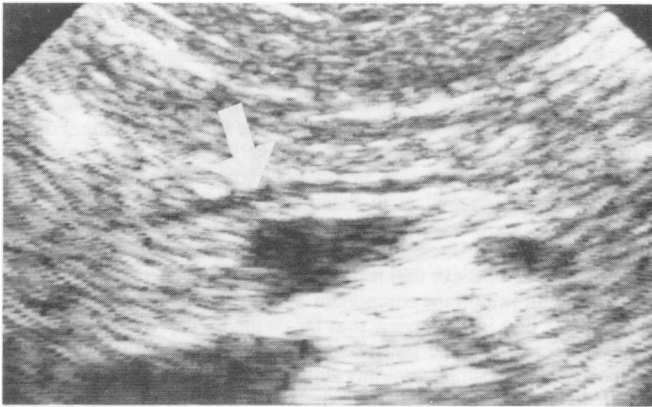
Ultrasound study performed in course of a positive Morphine Prostigmin Test. The pancreatic duct (arrow) which is normally barely visible has dilated to 3 times its prestimulation diameter.
